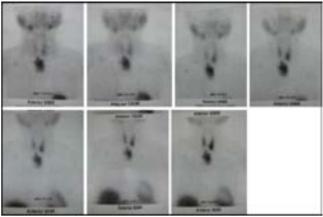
Parathyroid scintigraphy with Tc-99m sestamibi demonstrating persistent radiotracer accumulation at the substernal area, compatible with a hyperfunctioning parathyroid adenoma.
